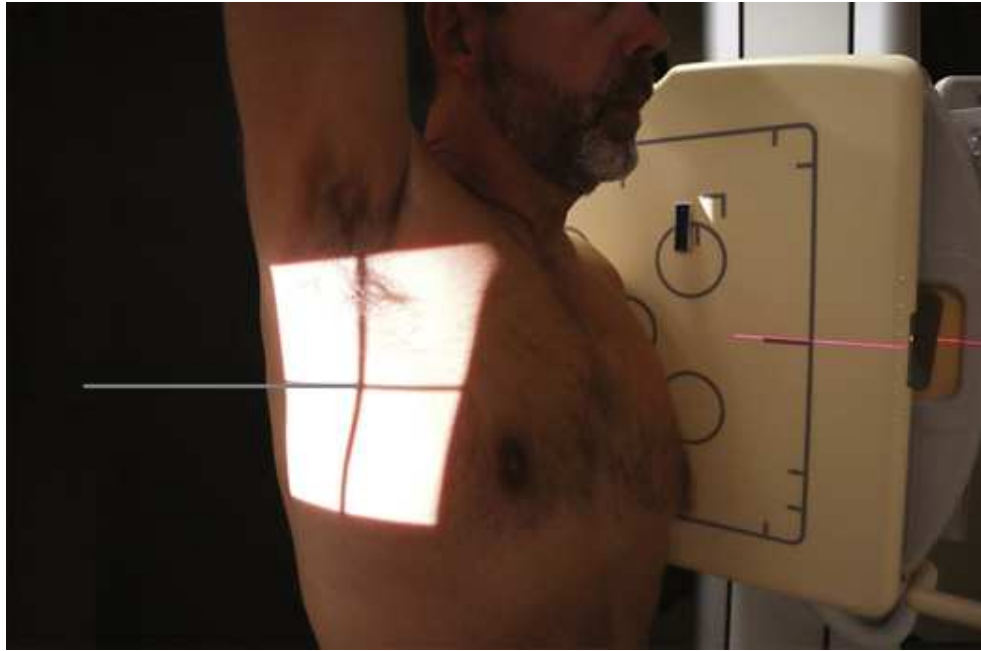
Upright transthoracic lateral shoulder: Lawrence method.
